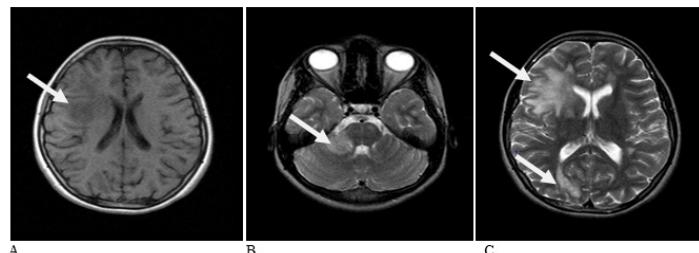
MRI. A. Hypointense lesions on T1-weighted images. B and C. Hyperintense lesions on T2-weighted images.
